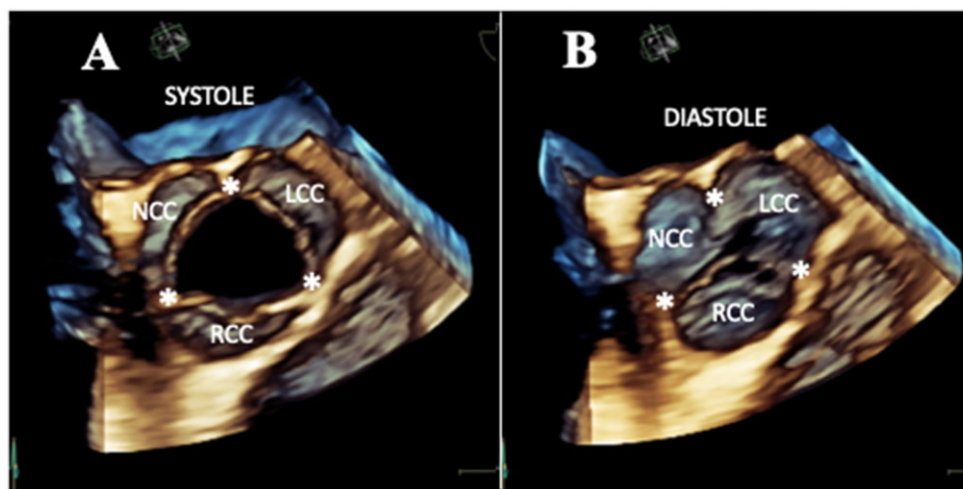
Transesophageal 3D images of normal aortic valves (AV) in systole (A) and diastole (B) as seen from the aorta. Each valve has three semi-lunar cusps and three commissures (asterisk)*. LCC, left coronary cusp; NCC, non-coronary cusp; RCC, right coronary cusp.
